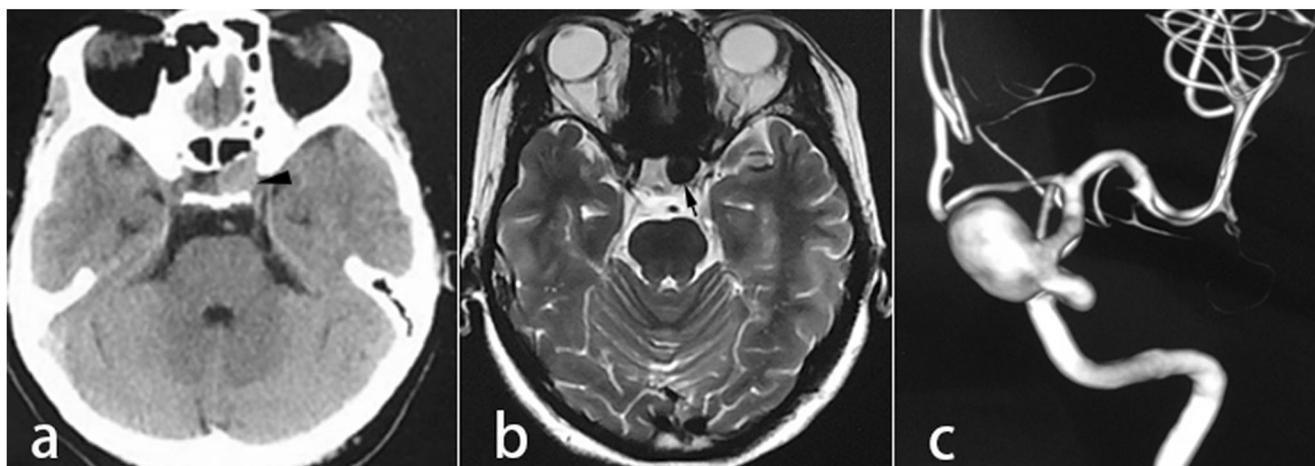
Imaging studies before surgery. a CT scan indicates a left sellar lesion (arrowhead). b MRI T2-weighted image indicates the lesion with flow void signal (arrow). c DSA 3-dimensional image indicates a left OA aneurysm
